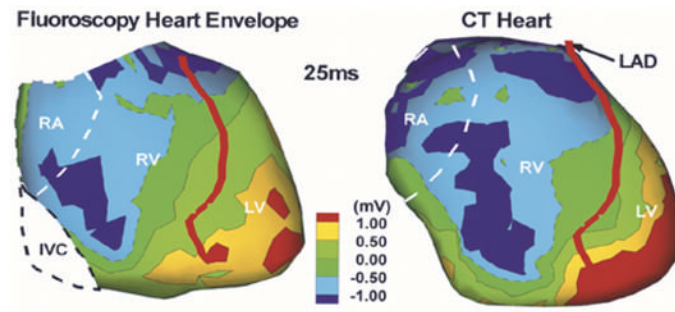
Noninvasively imaged epicardial potential map in a human subject using the fluoroscopy-reconstructed envelope (left) and CT heart (right). Image is obtained 25 ms after QRS onset. RA, right atrium; RV, right ventricle; LV, left ventricle; LAD, left anterior descending coronary artery.
